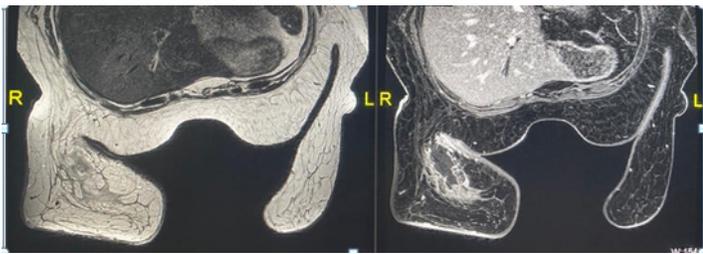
MRI-T2 WI with post contrast Fat suppressed T1 WI images showing loss of signal on fat suppression and peripheral contrast enhancement—impressive of fat necrosis. Subacute stage
